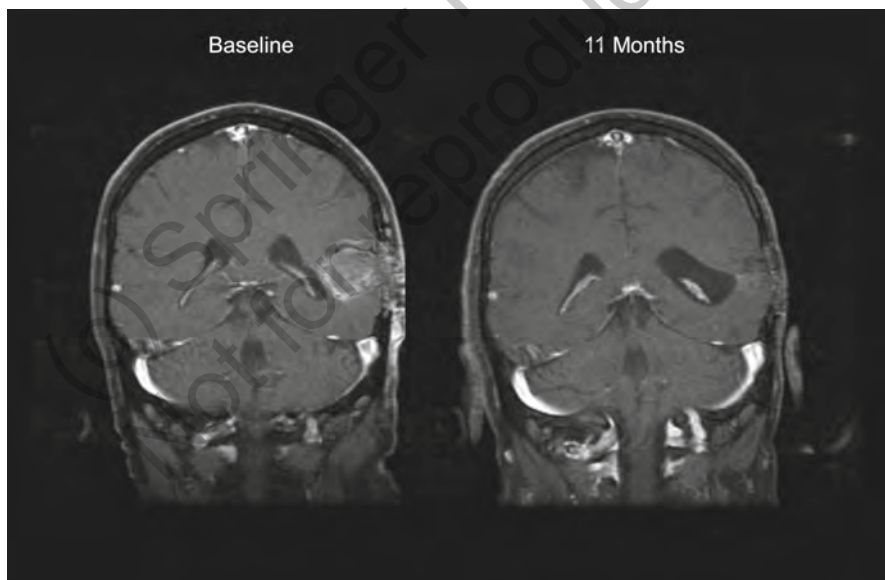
T1-weighted post-contrast MR images of a 55-year-old man with primary GBM which recurred for the third time after receiving radiotherapy with concomitant temozolomide, 2 cycles of adjuvant temozolomide, 3 cycles of bevacizumab with irinotecan, and 1 cycle of erlotinib and sorafenib. The subject had a partial response after 4 months of treatment with TTFields and remained stable for an additional 8 months while on therapy. Vymazal et al. Response patterns of current glioblastomas treated with tumor-treating fields. *Semin Oncol.* 41 Suppl 6:S14-S24, 2014. Elsevier
